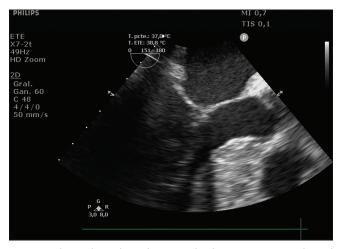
This mid-esophageal aortic valve long-axis transesophageal echocardiography view shows resolution of hypertrophy in the LVOT after surgery
